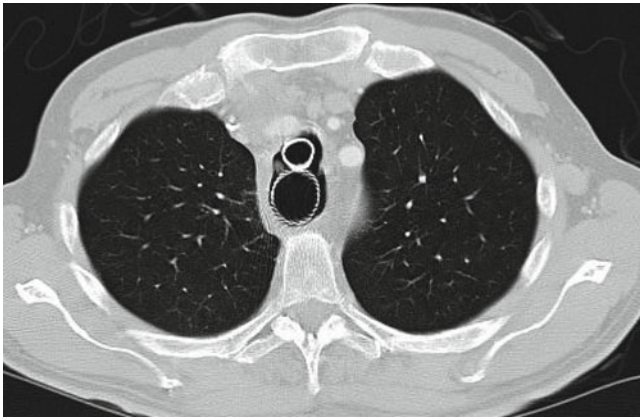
CT shows the relatively small contact zone between the two prostheses
